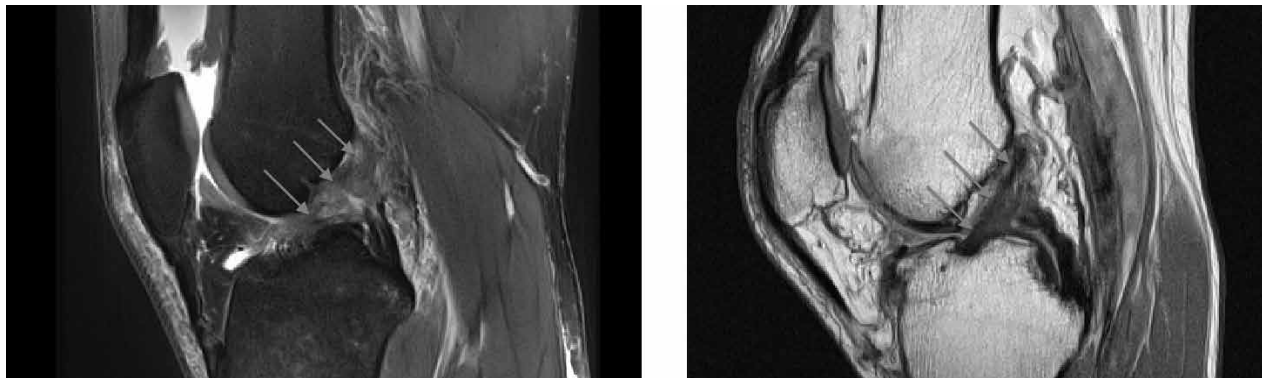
left side - MRI of the patient's injured knee - the lack of the continuous black line indicates a torn ACL; right side - continuous black line from tibia to femur indicates normal ACL in a healthy person.
